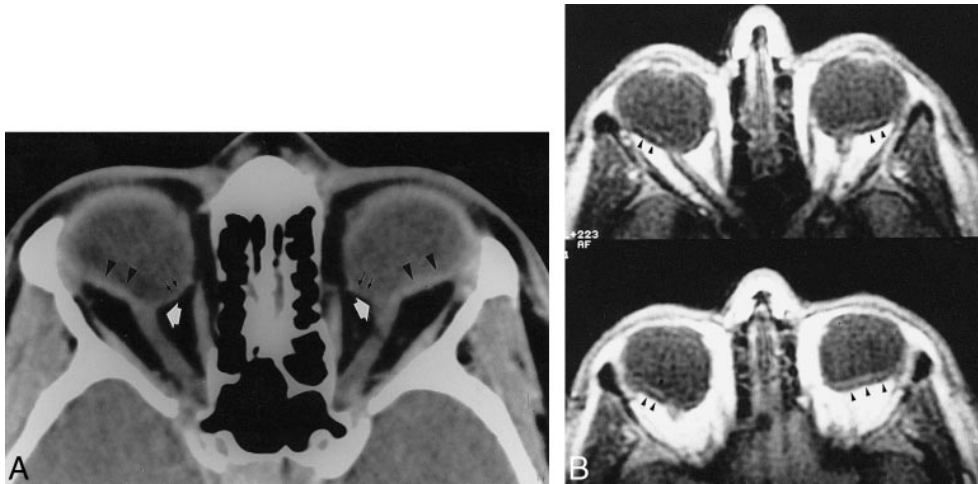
Axial CT (A) and T1-weighted MR (B) scans at level of optic nerve. Oblique insertion of optic nerve head can be appreciated (white arrows). Note ectasia of nasal sector of globes with posterior nasal wall thinning (double arrows) and flattened temporal aspect (arrowheads).
